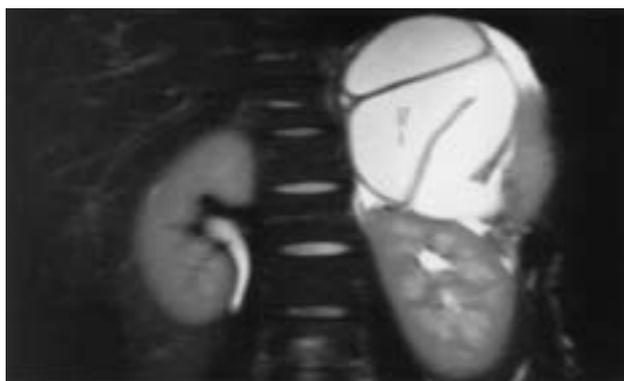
MRI examination demonstrates the retroperitoneal enteric duplication cyst with an infolding tubular structure.
